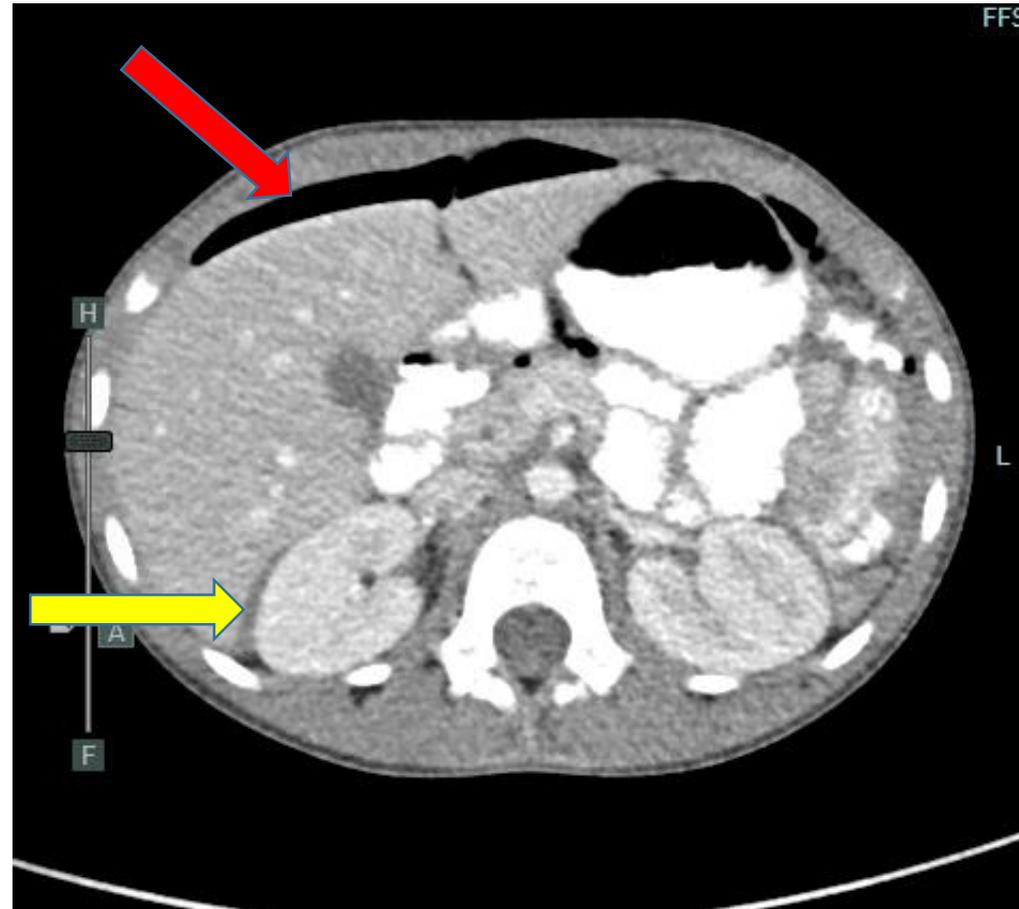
Axial view – CT abdomen/pelvis
